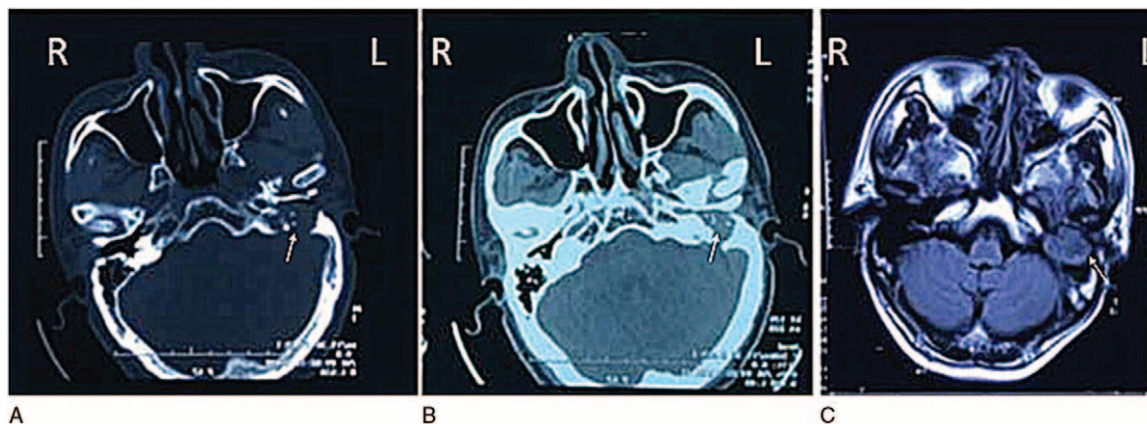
(A) Computed tomography (CT) of middle ear of Shanghai Seventh People's Hospital showing space occupying lesion in the right middle ear. (B) CT of the middle ear mastoid showed disappearance of right mastoid gas chamber, appearance of soft tissue shadow, and extensive destruction of the local bone. The soft tissue shadow was communicated with the middle cranial fossa and the cerebellar hemisphere. (C) The brain scan and enhanced MRI showed right middle ear mastoid mass, neoplastic lesion (cumulative right cranial fossa) and local mastoiditis. MRI=magnetic resonance imaging.
